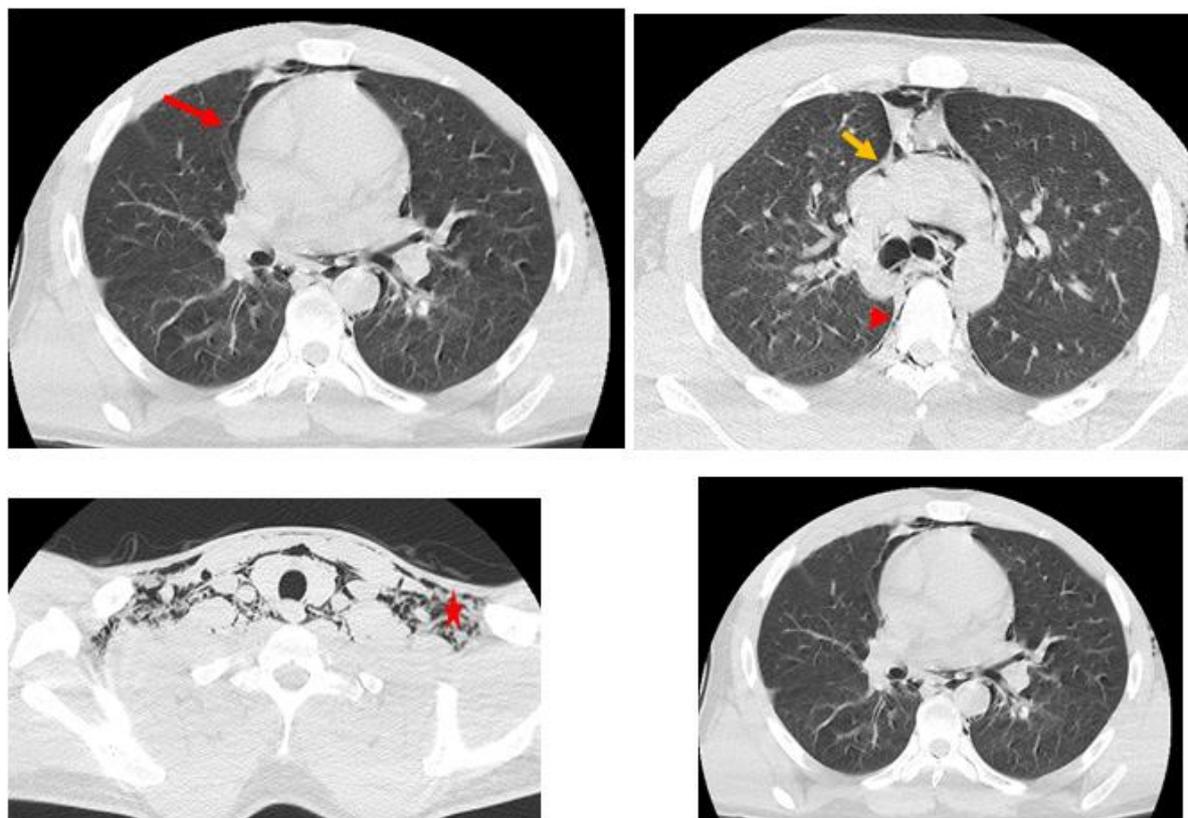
Chest CT scan with parenchymal window: Pneumo mediastinum of great abundance (yellow arrow) with pneumopericardium (red arrow); Bilateral pneumothorax (red arrowhead); Significant subcutaneous cervicothoracic soft tissue emphysema (star)
